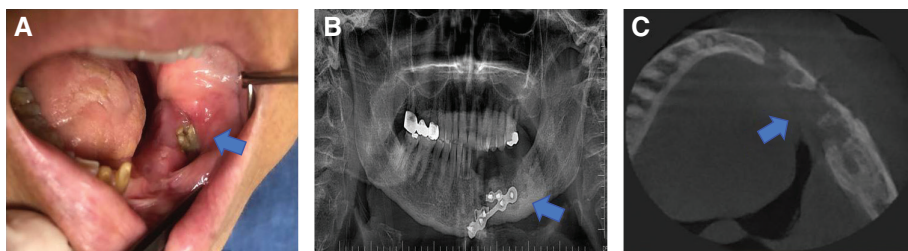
Osteoradionecrosis of the lower jaw in the left retromolar region (blue arrow). A: clinical intra-oral view. B: panoramic radiograph image. C: axial cone-beam computed tomography image.
